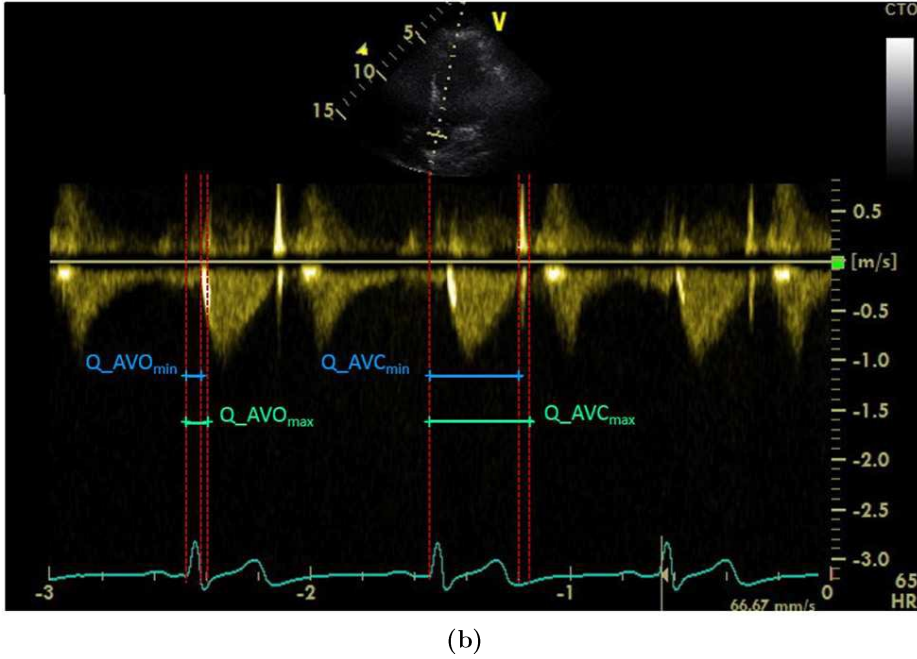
Examples of ECHO images: (a) M-mode; (b) Blood flow from ECHO Doppler. AVO and AVC indicate aortic valve opening and closure events, while MVO and MVC indicate mitral valve opening and closure events. Max and min subscripts represent the start and the end points of ECHO ranges for these events [38].
